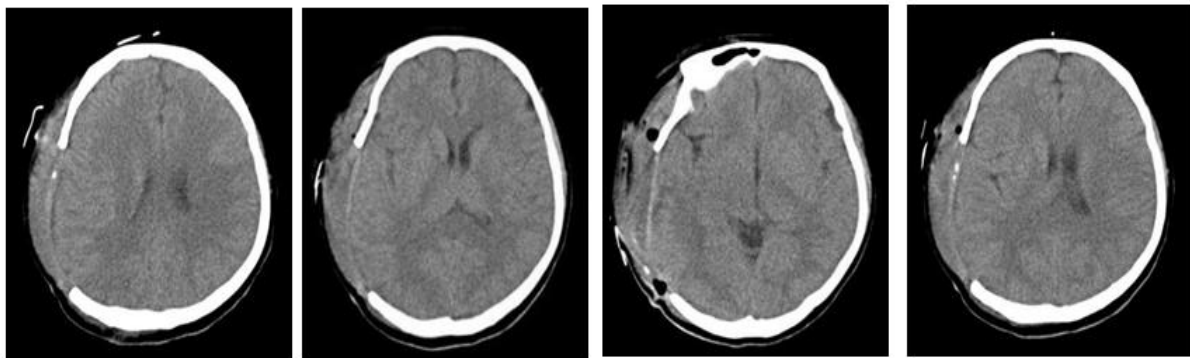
Cranial CT scanning showed bone was absent, and high-density internal fixator shadow was seen; local bone erosion, destruction, absence, and broken bone fragment shadow were seen; local bone in the right temporal lobe was lost in normal form and patchy low density shadow was seen with blurred edges.
